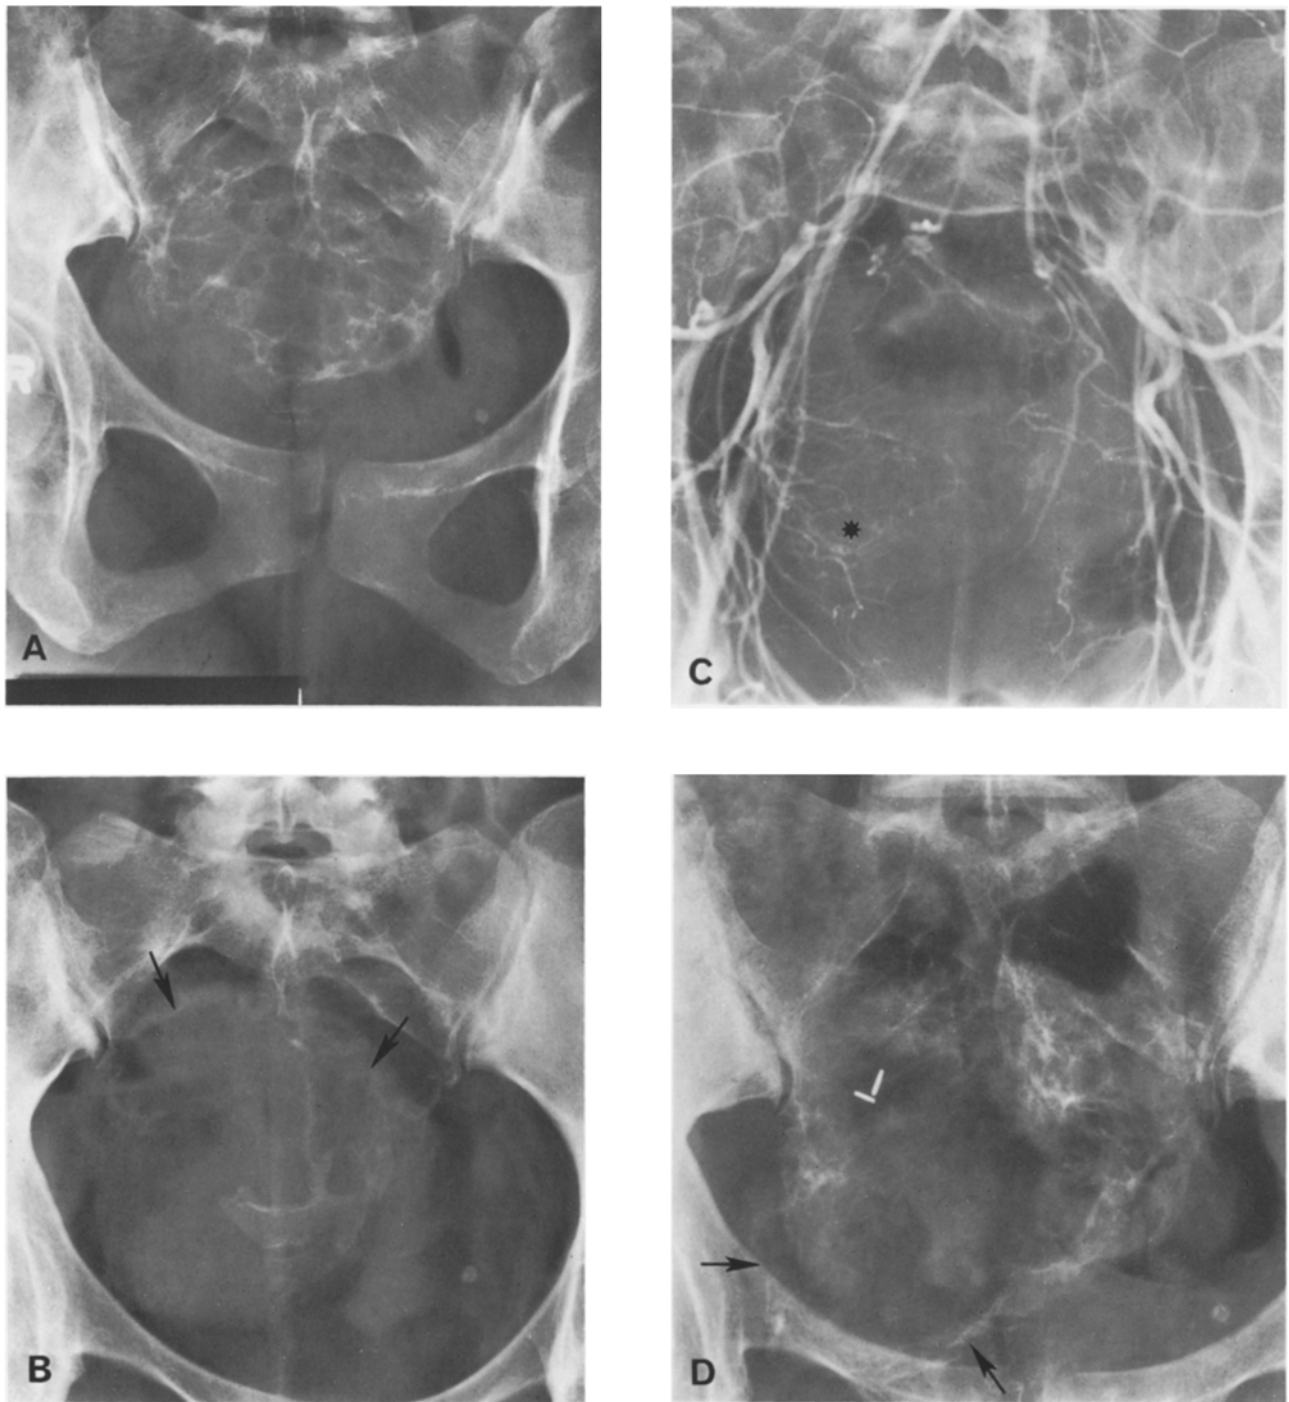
Aneurysmal bone cyst of sacrum. A Initial X-ray demonstrates an area of destruction in right lower aspect of sacrum. B Recurrent disease with lytic destruction of a large area of sacrum (*arrows*) is demonstrated one year later. C Arteriogram. Injection at aortic bifurcation reveals vascularity only in the lateral inferior aspect of the area of destruction (*star*). D Follow-up. Further recurrence after second surgical procedure occurred at vascular region only (*arrows*)
